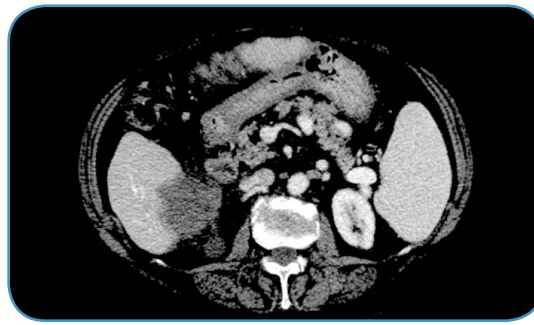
CT images in arterial phase showing complete necrosis of HCC with esophageic growth, adjacent to the right colon and kidney
